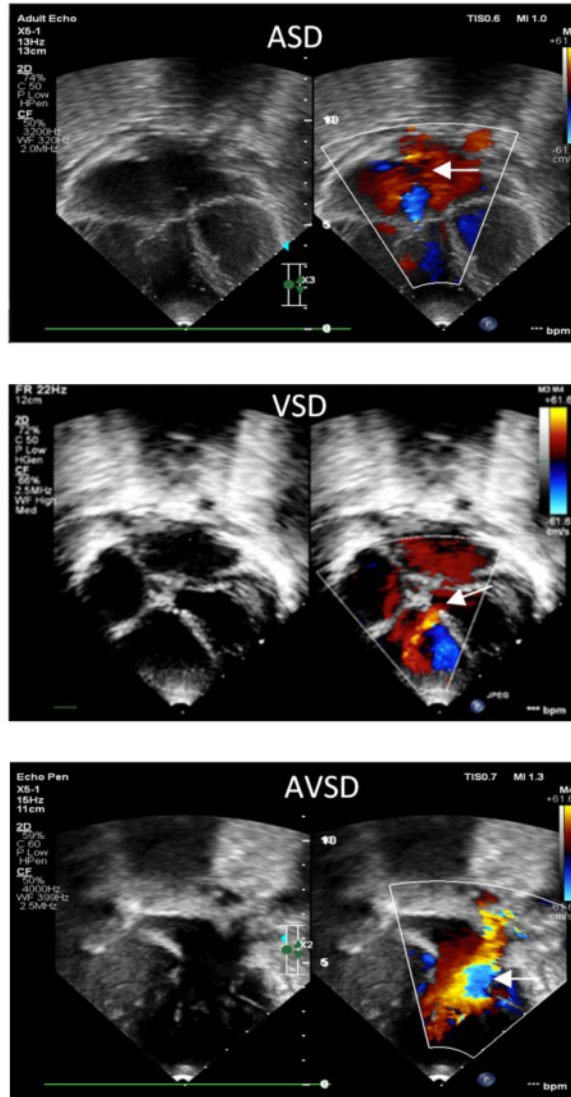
Echo Doppler revealed flow from the left to the right of ASD, VSD and AVSD.
